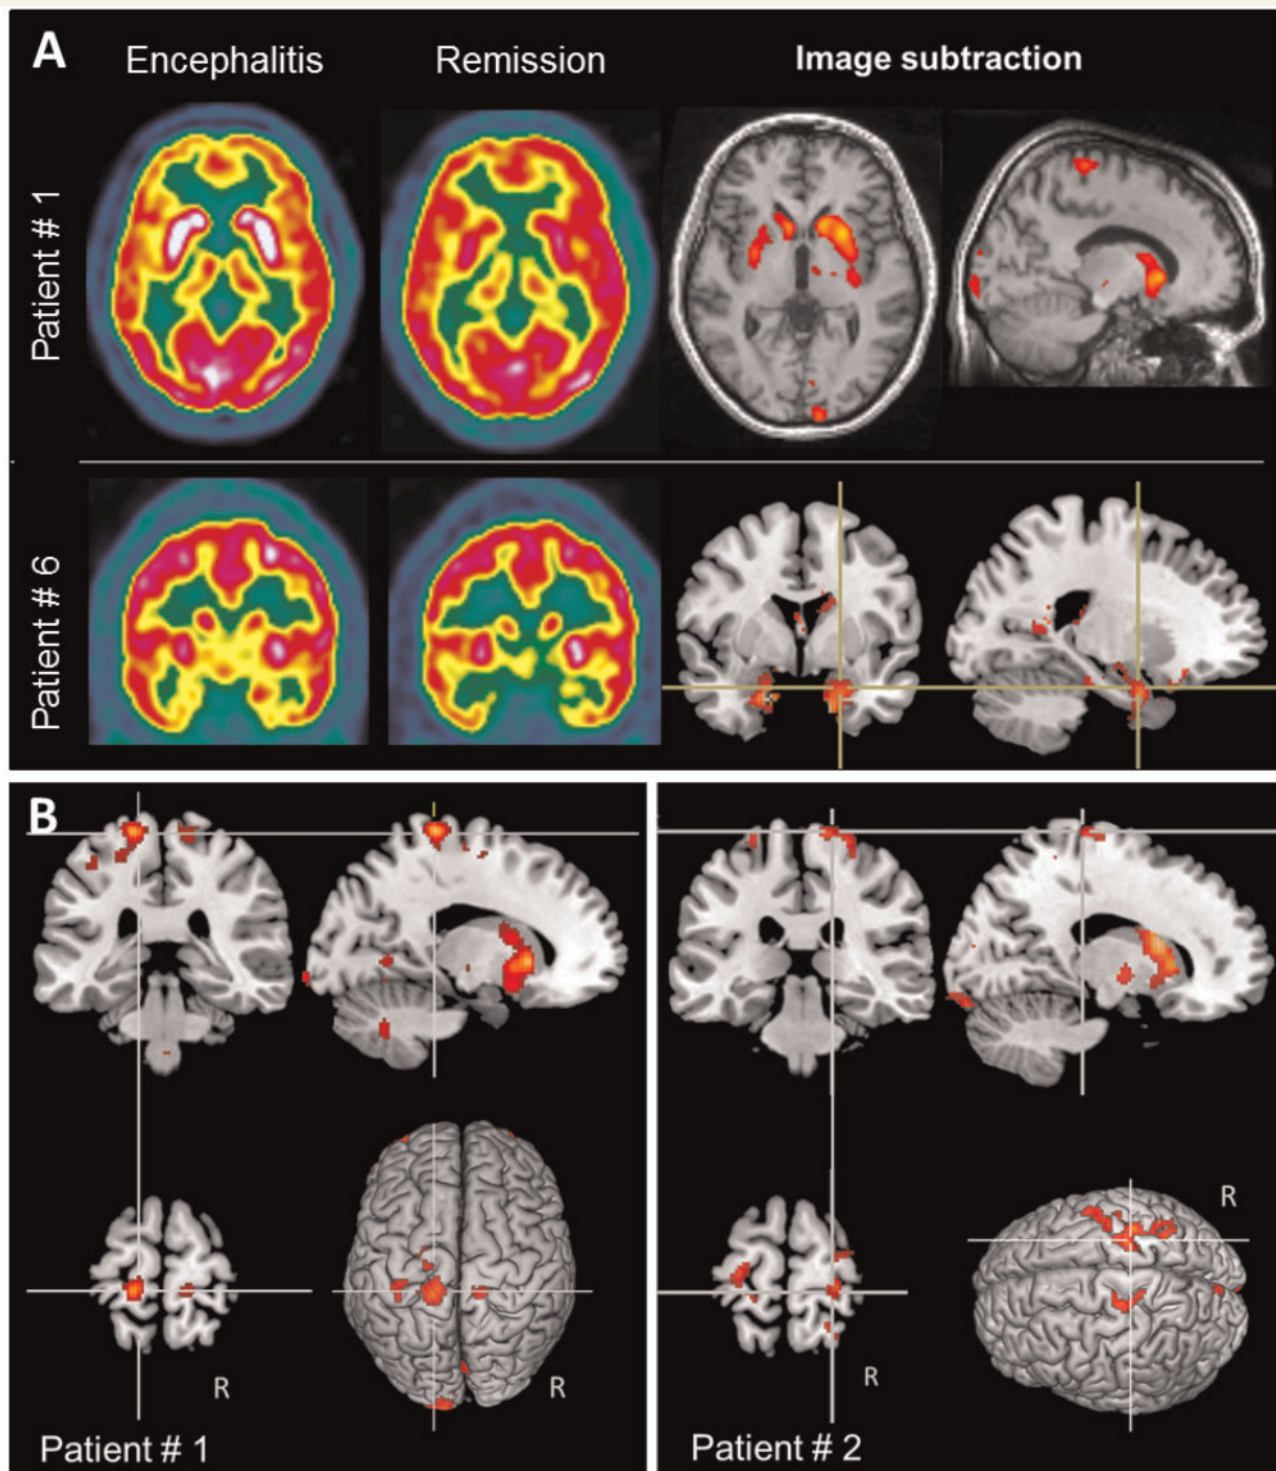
Hypermetabolism in the striatum, mesiotemporal and motor cortex. (A) FDG PET scans reveal striatal and mesiotemporal hypermetabolism during encephalitis. *Top:* Bilateral striatal hypermetabolism of Patient 1 during encephalitis disappeared during remission after treatment. *Bottom:* Mesiotemporal hypermetabolism of Patient 6 during encephalitis, associated with mesial temporal seizures, disappeared during remission. Axial slices are coloured with a French scale. Subtracted images (encephalitis – remission) superimposed on T₁-weighted MRI with hot colour scale showing only differences > 1.5 standard deviations (SD). (B) Hypermetabolism in primary motor cortex during encephalitis. Patients 1 and 2, with TDS affecting upper limbs bilaterally, exhibited a bilateral hypermetabolism in primary motor cortex. Metabolic changes in Patient 2 also affected the left premotor and sensorimotor cortices. The coronal views reveal bilateral striatal hypermetabolism in both patients. Regions of significant metabolic changes (z-score > 1.5) shown on three orthogonal views and on 3D volume renderings made with MRICro software.
